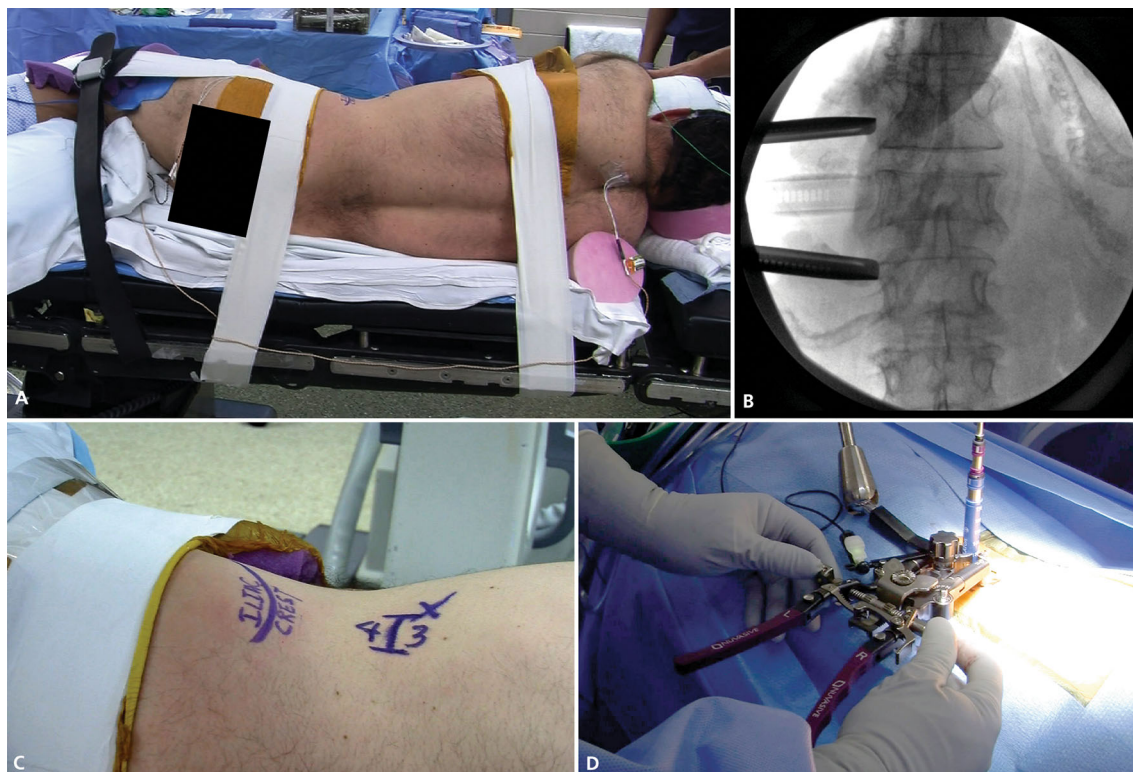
a Operating room picture demonstrating positioning of the patient in relation to the table break. b AP radiograph demonstrating central spinous processes with equidistant pedicles. d Picture demonstrating site of incision in relation to the costal angle and the iliac
